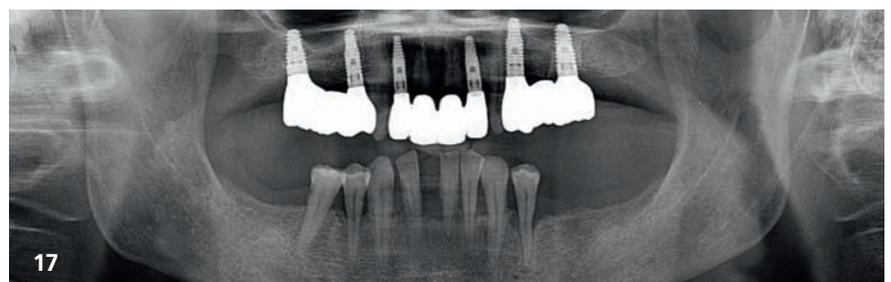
Frontal aspect of the definitive prosthetic restorations, showing good aesthetic conditions with no signs of soft-tissue complications after insertion. Fig. 15: Right lateral aspect of the restorations. Fig. 16: Left lateral aspect of the restorations. Fig. 17: Final radiograph with definitive prosthetic superstructures in place.
